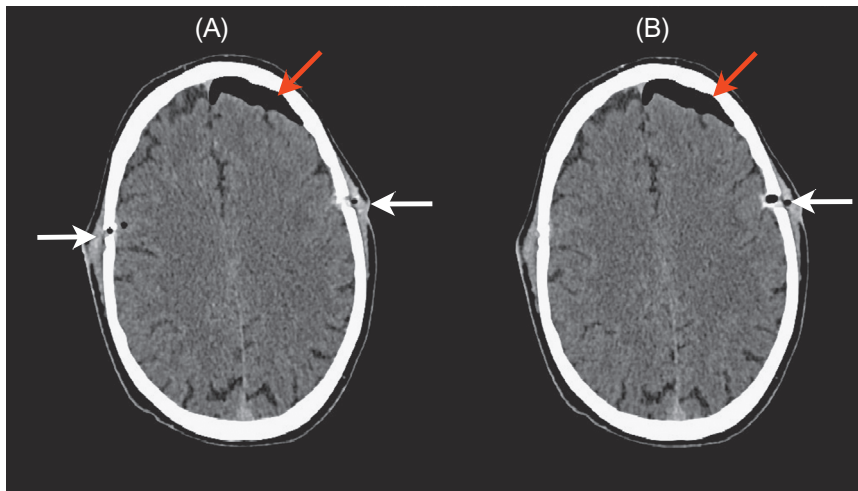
(A and B) Axial computed tomography (CT) head demonstrating full-thickness cranial vault perforations (white arrow) and left-sided, pneumocephalus (red arrow). (Color version of figure is available online.)
